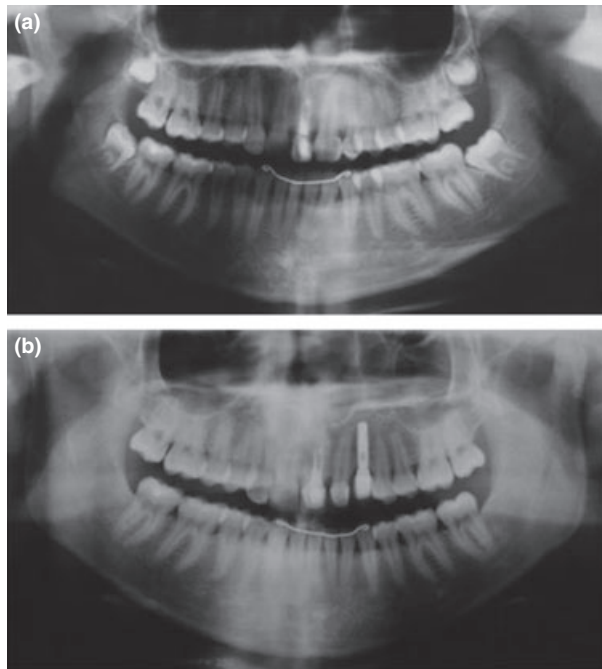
(a) Final radiography with 1 years of follow up. (b) Final radiography with 5 years of follow up.
